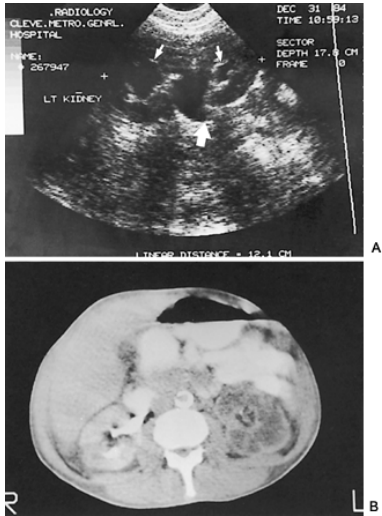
18. A: Longitudinal scan demonstrating hydronephrosis secondary to ureteropelvic junction obstruction (*large arrow*). Note dilated calyces (*small arrows*). B: Computed tomography scan of same patient showing hydronephrotic kidney.
